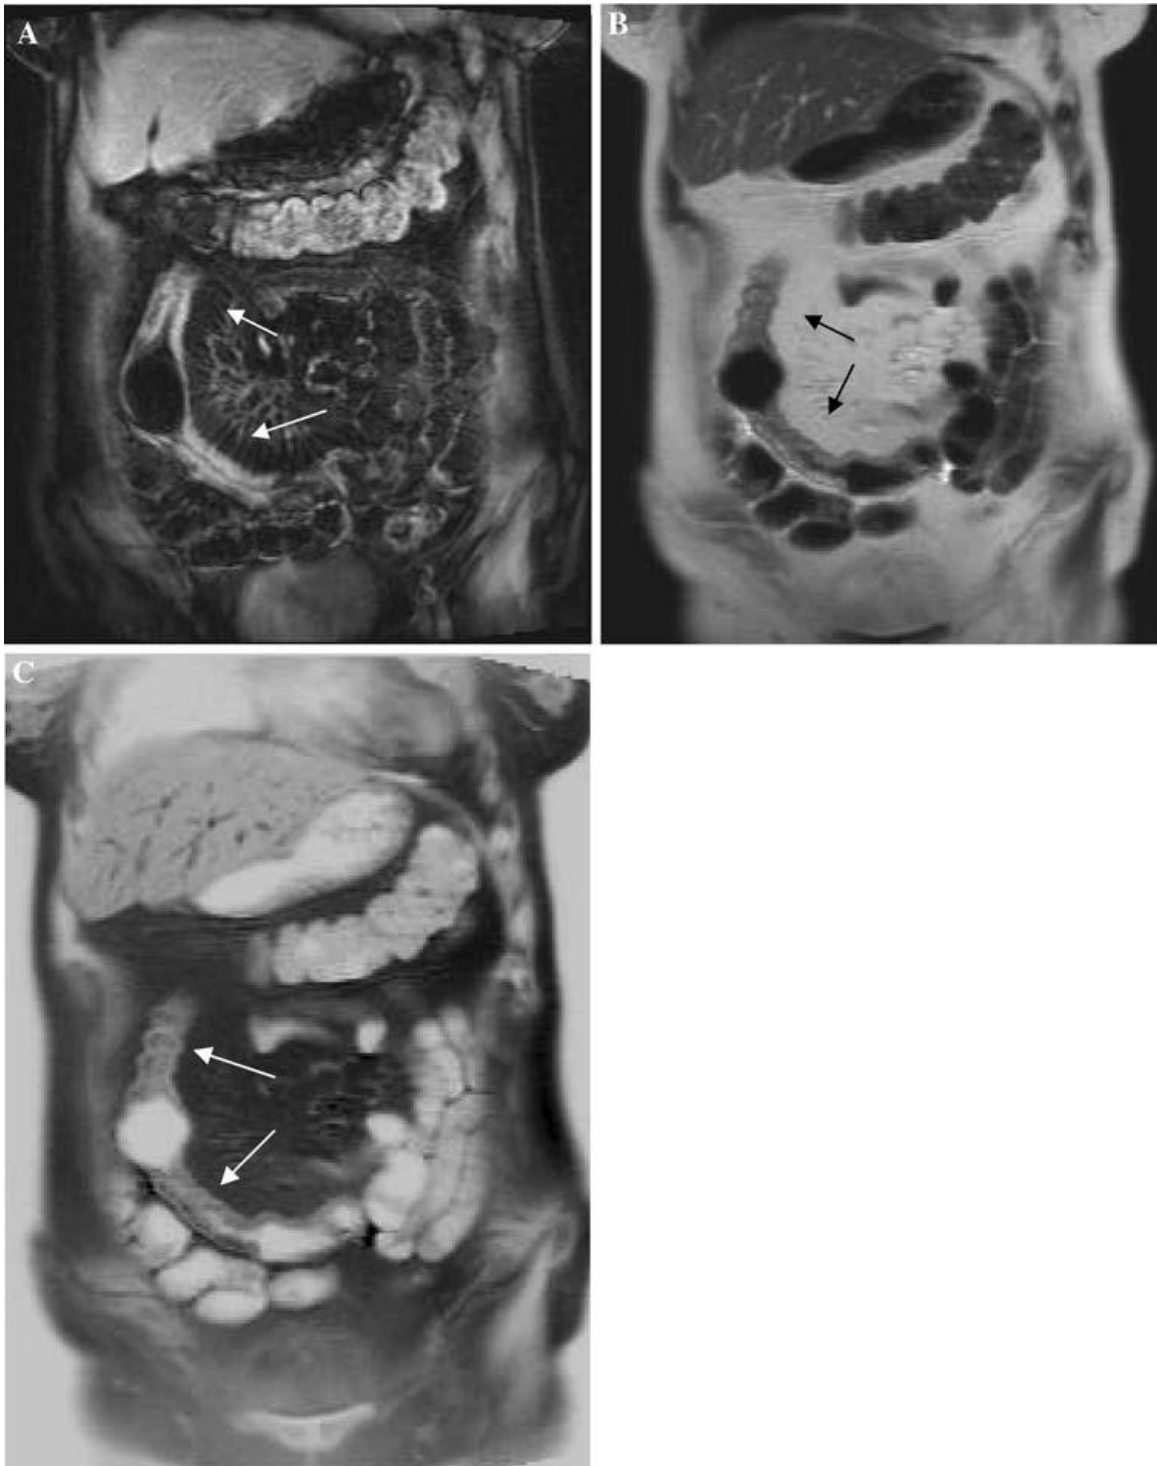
A 60-year-old woman, with fibrostenotic CD of the mid-distal ileum. A, B. Short strictures alternate with brief prestenotic dilations, typical findings of fibrostenosing CD. On the left (A) coronal T1-weighted VIBE Gd-enhanced image: two short enhancing stenotic ileal segments are clearly evident (white arrows), with a short dilation in between. Local increased mesenteric vascularity is present. On the right (B) coronal T2-weighted HASTE image: the two short enhancing stenotic ileal segments are clearly evident (arrows), similarly the Gd-enhanced image, with a short dilation in between. Coronal T2-weighted HASTE “inverted” image (C): probably, the bright lumen effect better shows the alternating strictures (arrows) and dilations; however, information is exactly the same of image (B).
